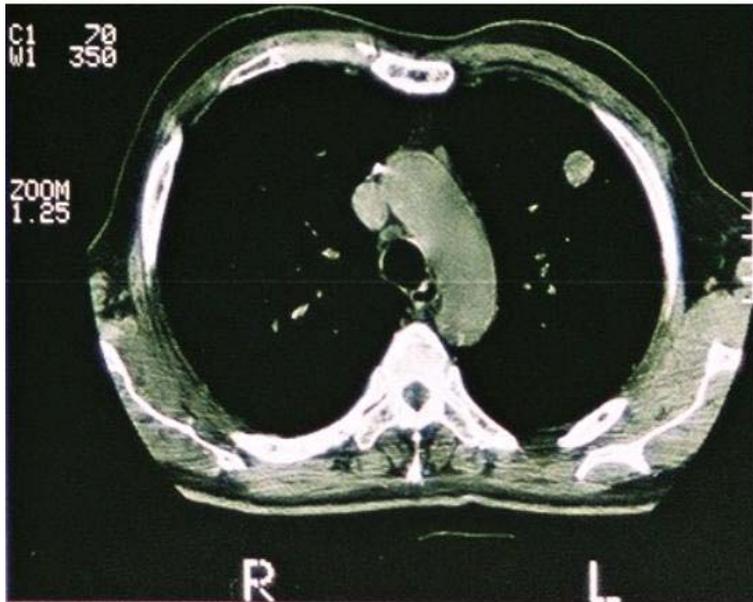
and Figure 2B: Sixty-six year old man presented with a solitary pulmonary nodule of the right lung. CT showed a 2.4 cm solitary pulmonary nodule in the right upper lobe. Both the planar views and SPECT demonstrated increased uptake in a lesion in the right lung (score 2.5, solid arrow), corresponding to the lesion on the CT.
